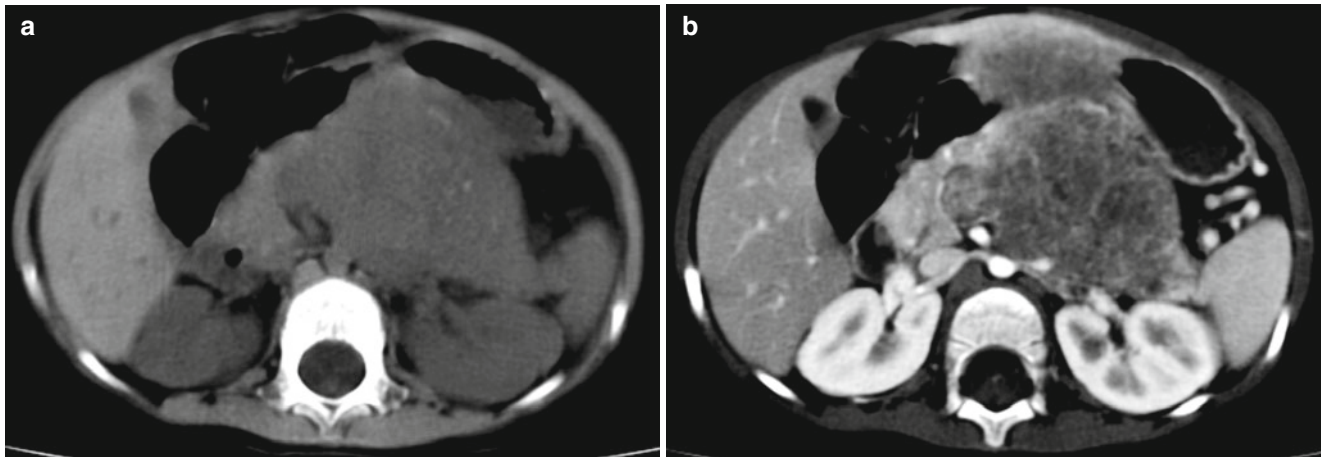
Pancreatoblastoma in a 1-year-old girl. (a) Pre-contrast abdominal CT shows huge mass from pancreas body with internal tiny calcifications. (b) Post-contrast abdominal CT shows heterogeneous enhancement of the mass
